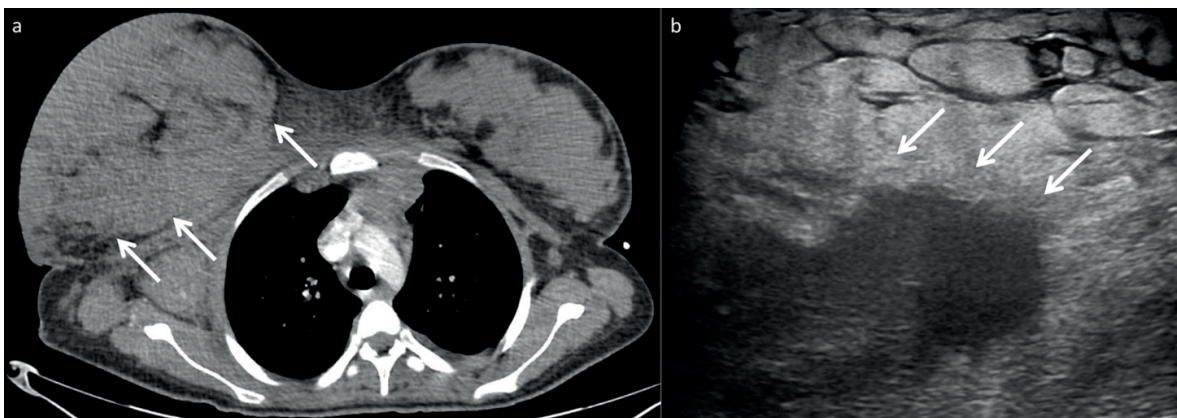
A 16-year-old girl with Burkitt lymphoma. (a) Axial contrast enhanced chest computerized tomography shows large heterogeneous breast mass (arrows). (b) Breast ultrasonography demonstrates hypoechoic ill-defined breast mass (arrows) with soft tissue edema.
